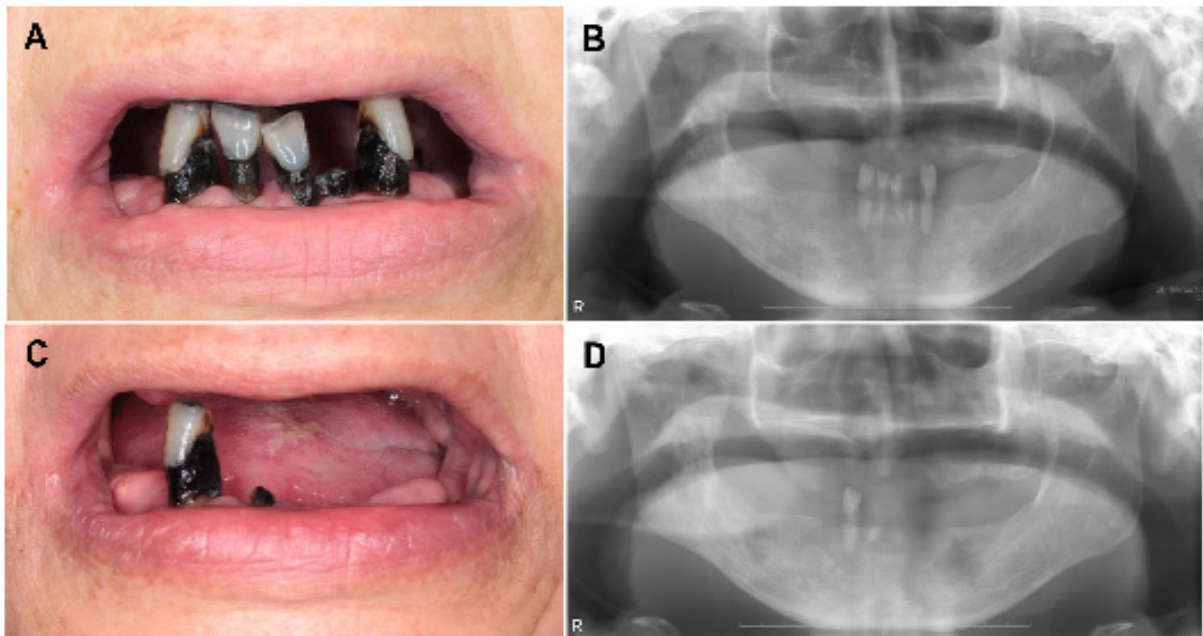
Clinical images of radiation-induced dental caries. This patient received concurrent chemoradiotherapy (CCRT) (70 Gy/35 fractions and cisplatin) for right maxillary carcinoma (squamous cell carcinoma, cT4bN2cM0). Intraoral image (A) and panoramic radiography (B) at 4 years after completion of CCRT. Radiation caries is evident at cervical areas of mandibular anterior teeth. Intraoral image (C) and panoramic radiography (D) at 6 years after completion of CCRT. Anterior teeth with radiation caries are lost.
